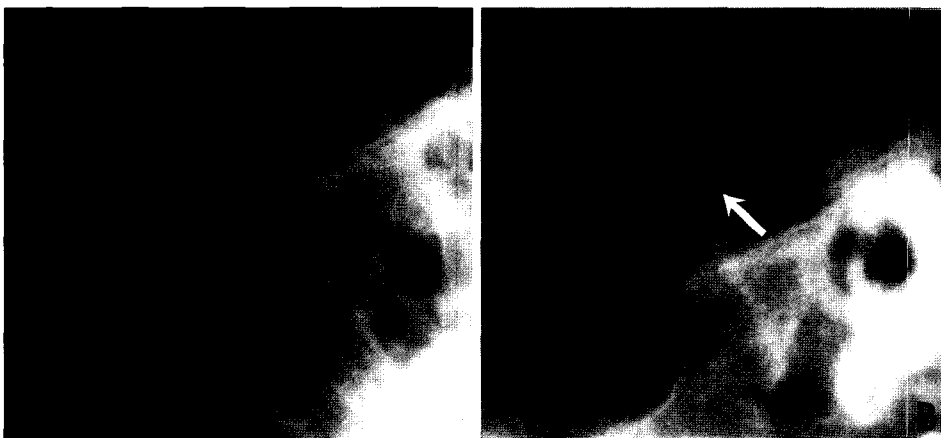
Transcranial radiographs show sclerosis on the articular eminence at unaffected side in same patient as Fig. 4. A, immediately after treatment B, 21 months after treatment
